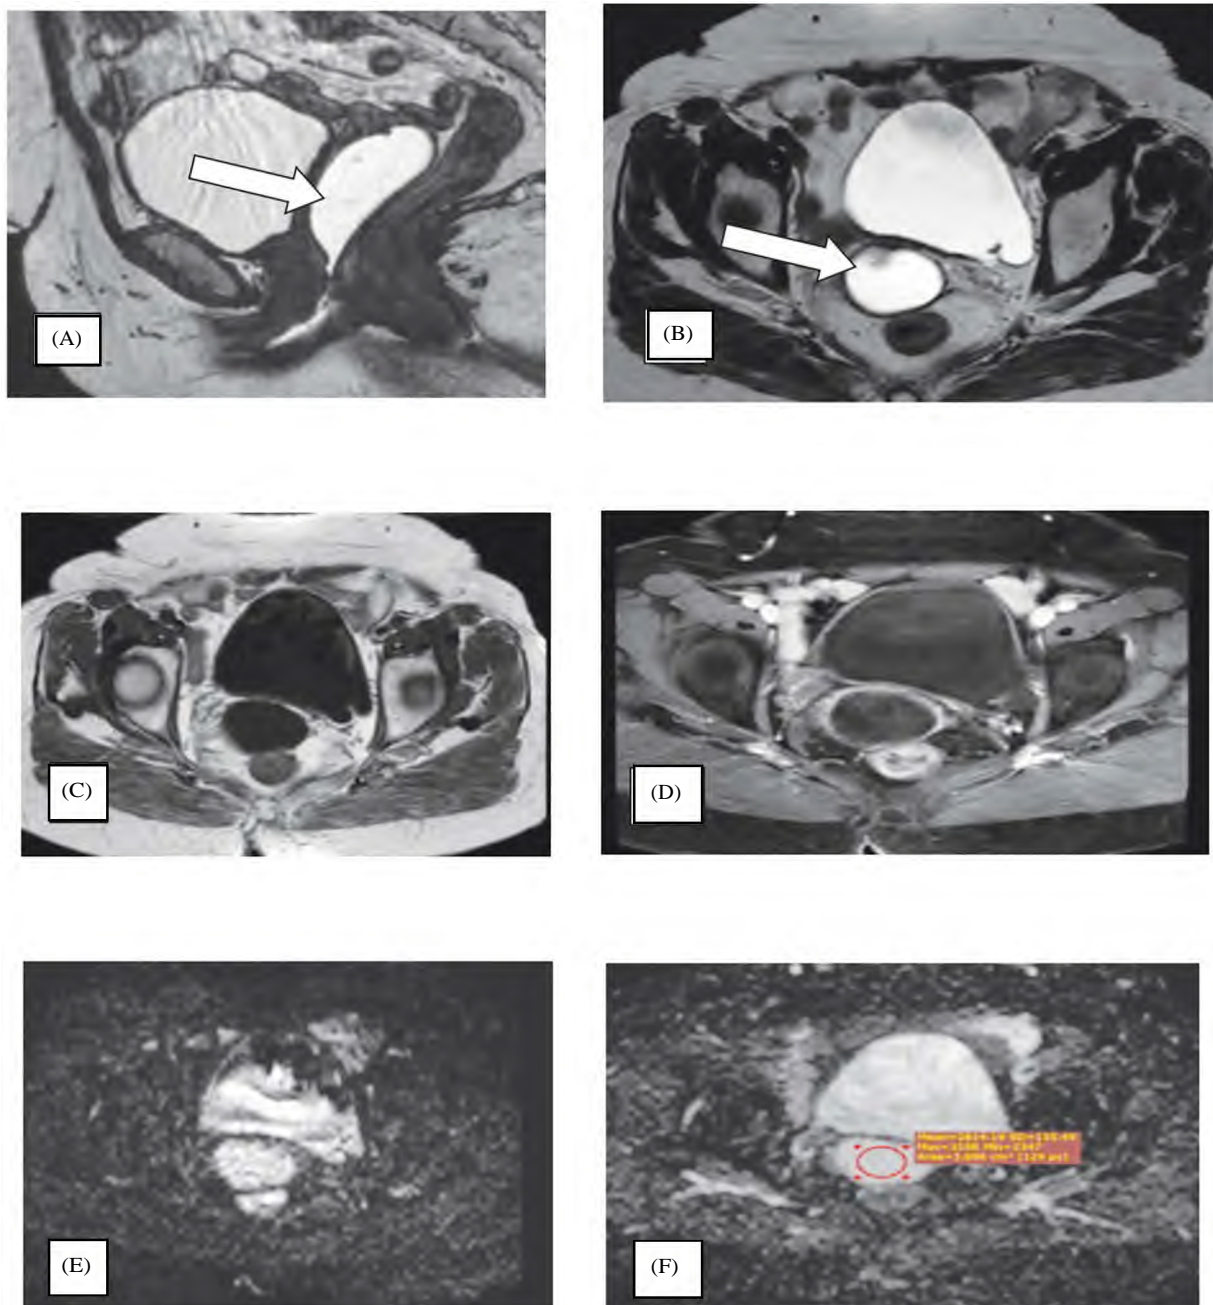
A 62-year-old female. Presented with pelvic heaviness. sagittal T2WI. (A) Axial T2WI (B) and axial T1WI. (C) Cystic vaginal lesion is seen eliciting low signal in T1WIs and high signal in T2WIs. Post-contrast. (D) It shows no enhancement. DWI and ADC image. (E,F) The lesion shows a high signal on DWI and a high signal on the corresponding ADC maps (T2 shine through). ADC value was (Mean $2.8 \times 10^{-3} \text{ mm}^2/\text{s}$). The pathology was a simple benign cyst of the vagina.
